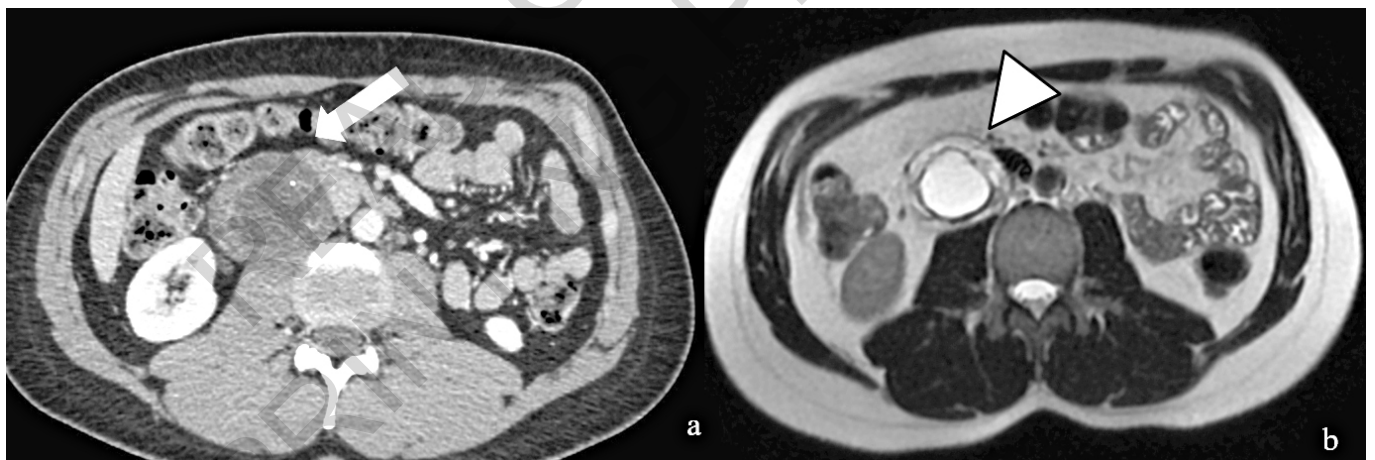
Retroperitoneal paraganglioma with cystic degeneration. Axial contrast-enhanced CT image (a) shows a low-attenuation mass with tiny and curvilinear calcifications (arrow). Axial T2-weighted MR image (b) shows the mass to be heterogeneously hyperintense (arrowhead), with an internal cystic formation.
